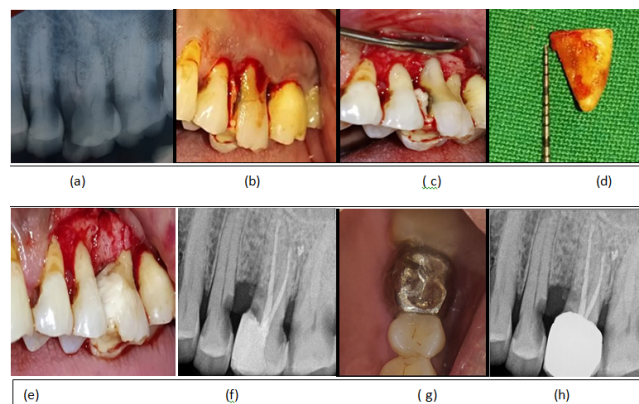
(a) preoperative radiograph.(b)incisions placed.(c)subgingival caries location.(d) resected root piece.(e)ging restoration done.(f)one month follow up.(g)crown placement.(h)six months follow up.
